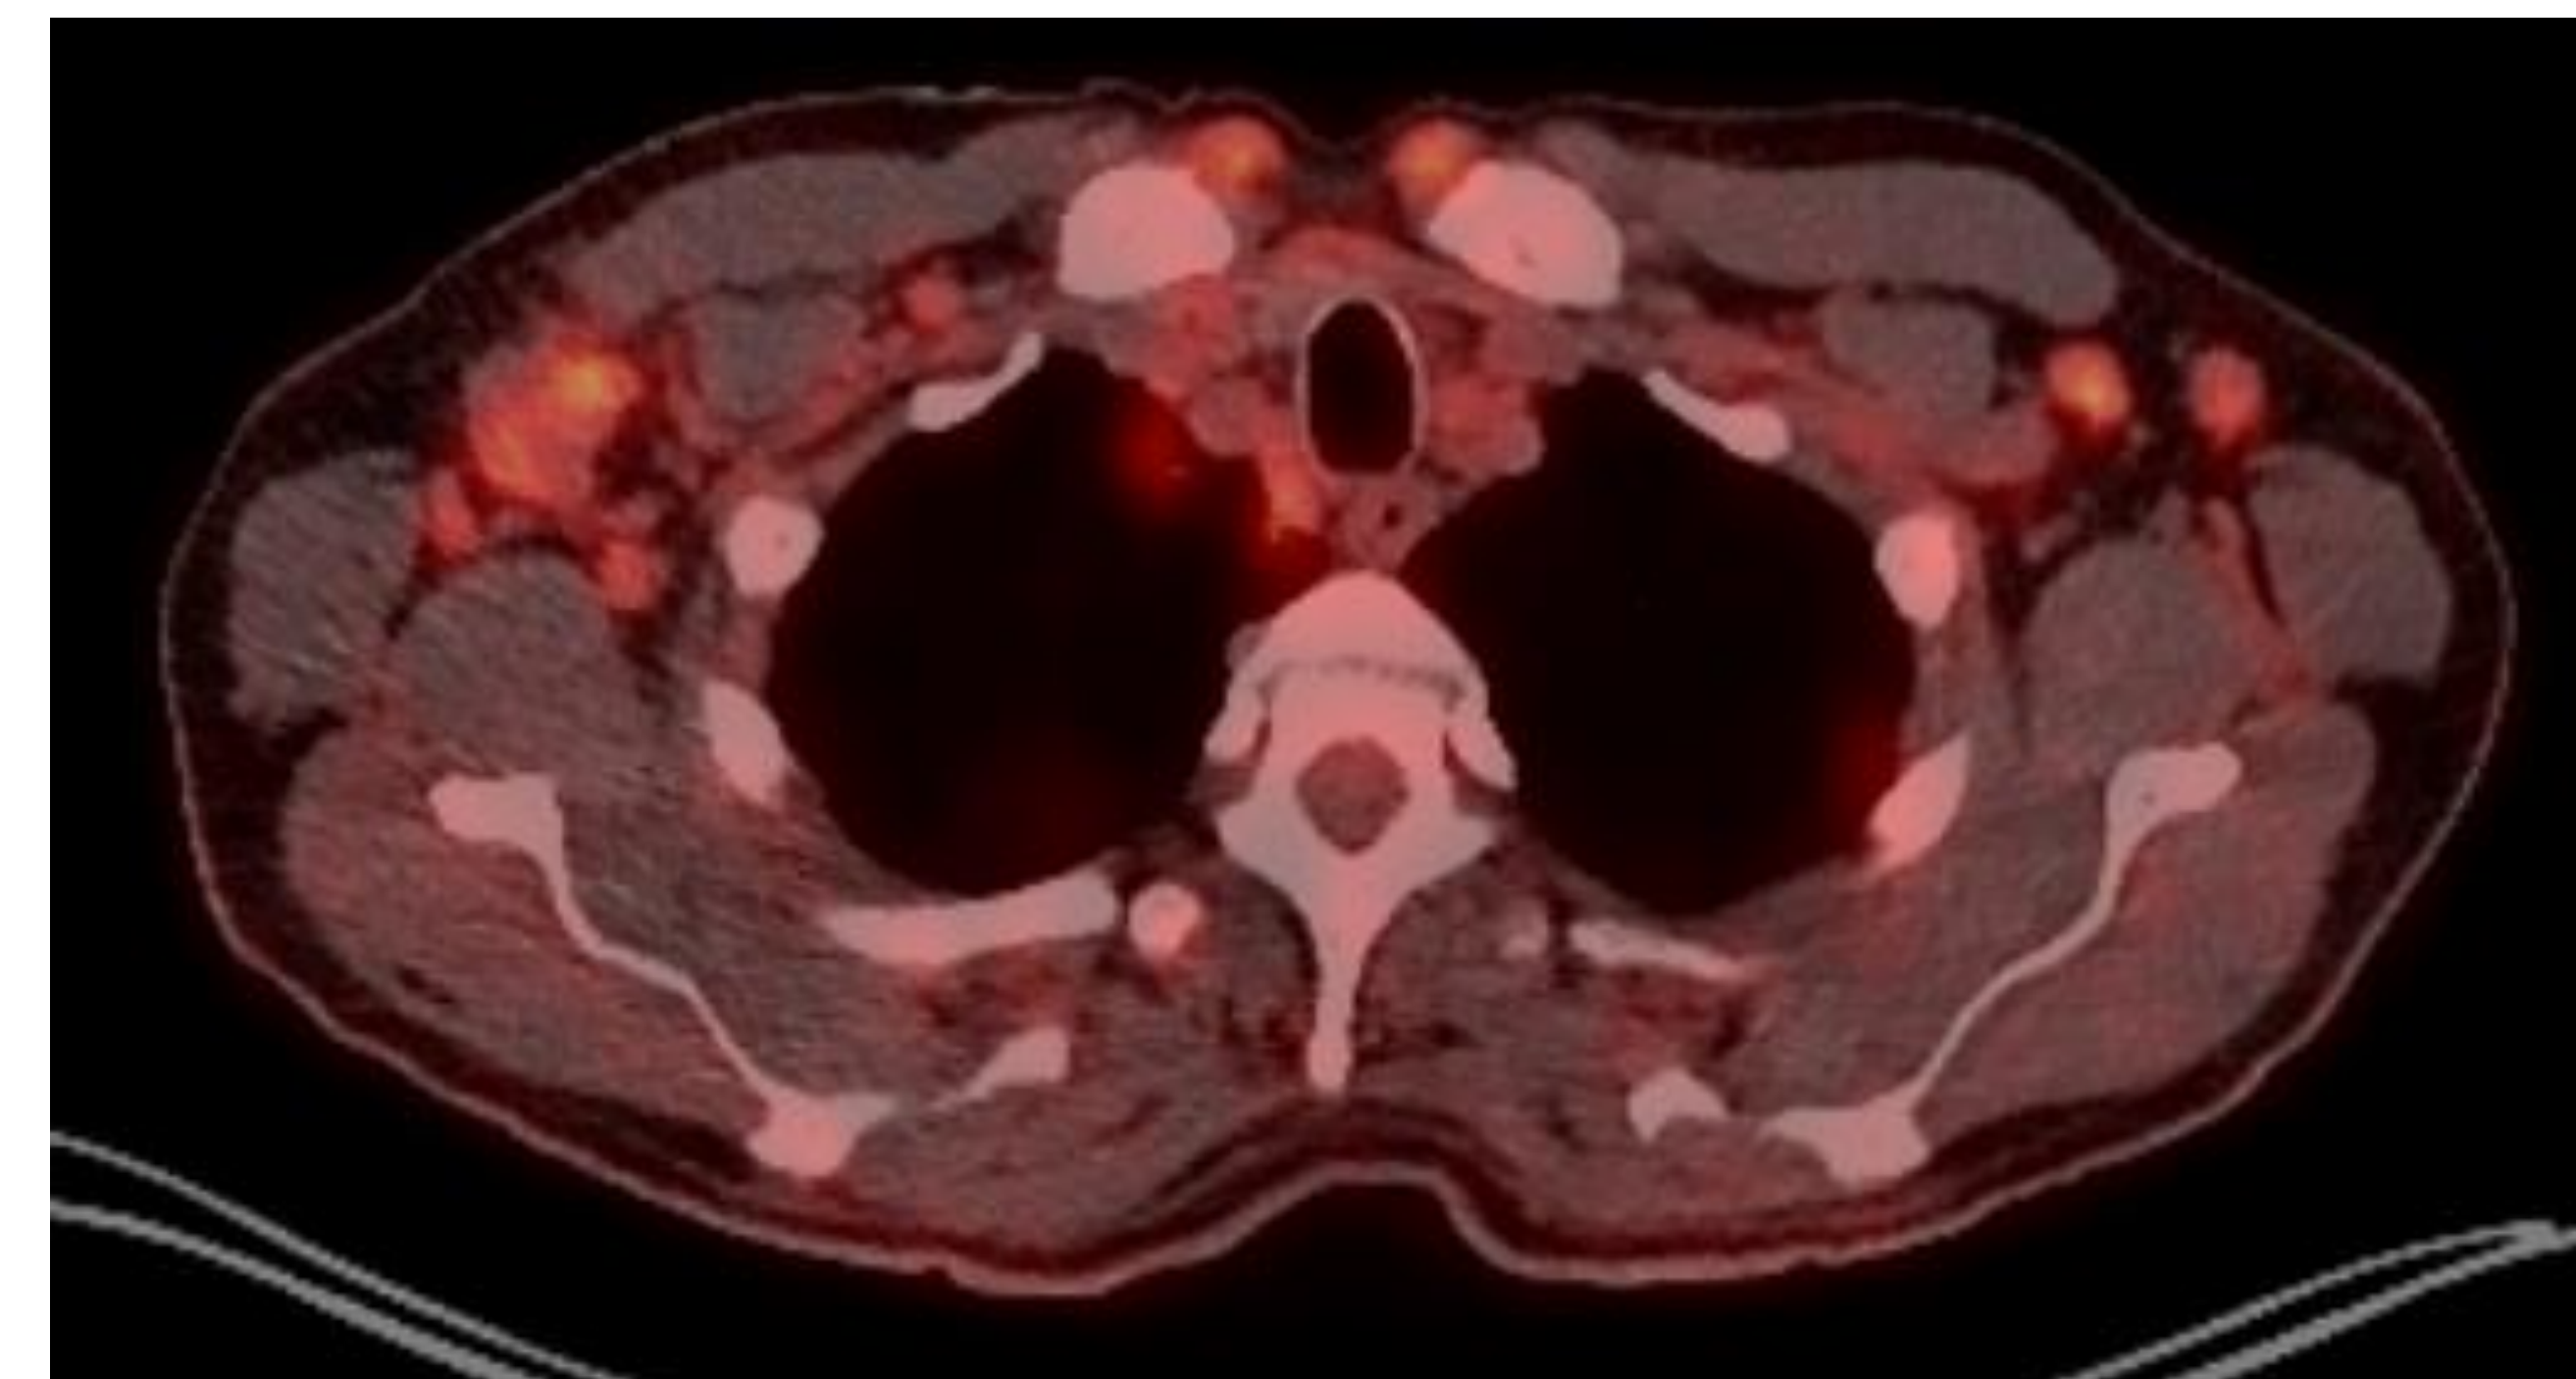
FDG-PET-CT showing moderate metabolic activity (SUVmax: 3.2)
